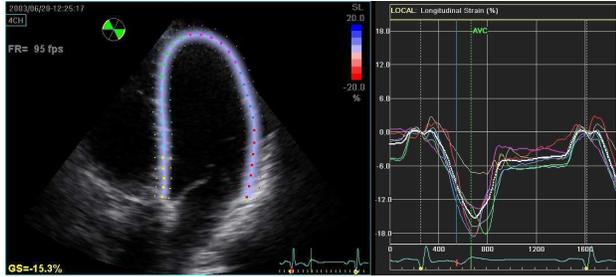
Example of GE Echopac display showing color strain map overlay (right) and segmental longitudinal strain waveforms (left) of a 4-chamber echocardiographic acquisition.
